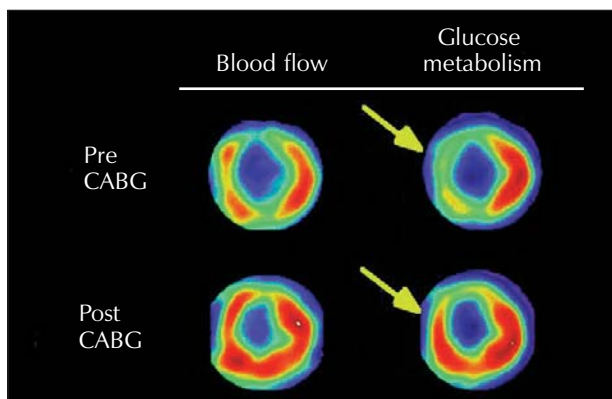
PET images of a human heart in short-axis views obtained in corresponding midventricular levels before and after coronary artery bypass surgery (CABG). The images have the same orientation as those of Figure 1. Images of blood flow (left column) were obtained with ^{13}N -ammonia and images of glucose metabolism (right column) with ^{18}F -deoxyglucose. (Top panel): A patient with three-vessel coronary artery disease and a severe wall motion abnormality in the anterior and septal walls. The resting flow images (left) demonstrate a small perfusion defect in the anterior wall and near-normal perfusion in the interventricular septum. A $^{99\text{m}}\text{Tc}$ sestamibi perfusion scan (not shown) demonstrated exercise-induced ischemia in these regions. Glucose metabolism in the anterior and septal walls is markedly reduced compared with normal myocardium (lateral wall). (Bottom panel): Same patient 4 weeks after CABG. Blood flow and glucose metabolism are largely homogenous. A 2-D echocardiogram post CABG demonstrated improvement in systolic wall motion in the anterior and septal regions.
